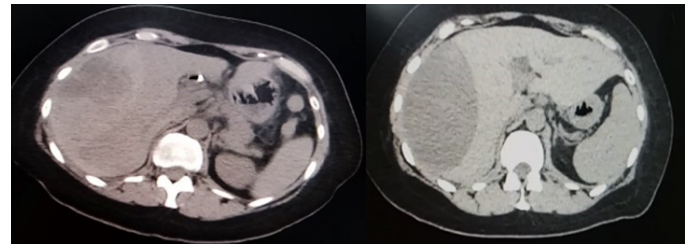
Follow-up computed tomography in axial plane at A) one week and B) 2 months.
